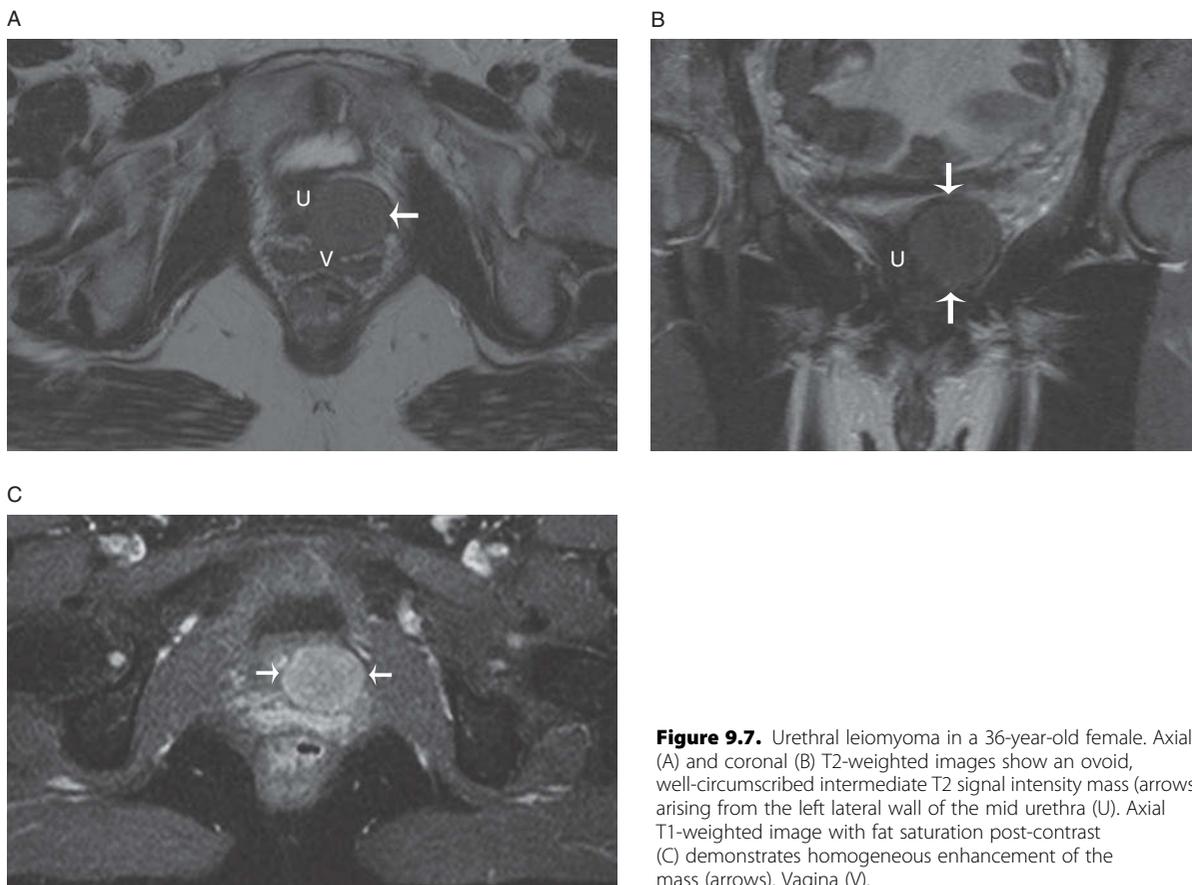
Urethral leiomyoma in a 36-year-old female. Axial (A) and coronal (B) T2-weighted images show an ovoid, well-circumscribed intermediate T2 signal intensity mass (arrows) arising from the left lateral wall of the mid urethra (U). Axial T1-weighted image with fat saturation post-contrast (C) demonstrates homogeneous enhancement of the mass (arrows). Vagina (V).
